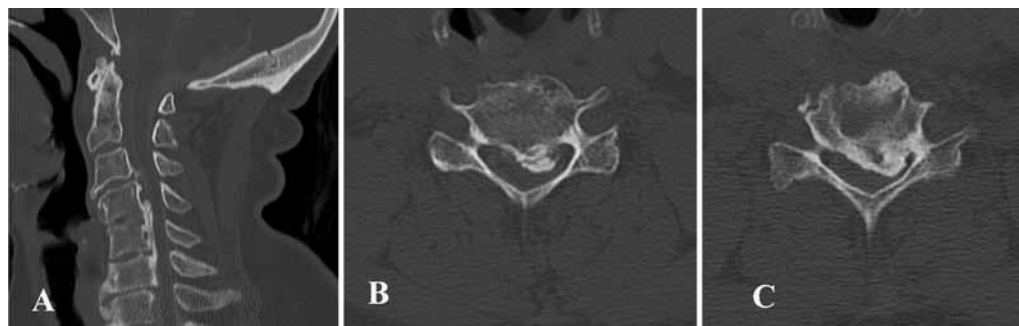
Case 5. Preoperative images. This 59-year-old woman was found to have cervical spondylitic myelopathy and OPLL. A: Sagittal CT reconstruction demonstrating continuous OPLL at the C4–6 levels. B and C: Axial CT images revealing severe spinal canal stenosis due to OPLL at multiple levels. There is also evidence of DISH on the sagittal and axial images.
